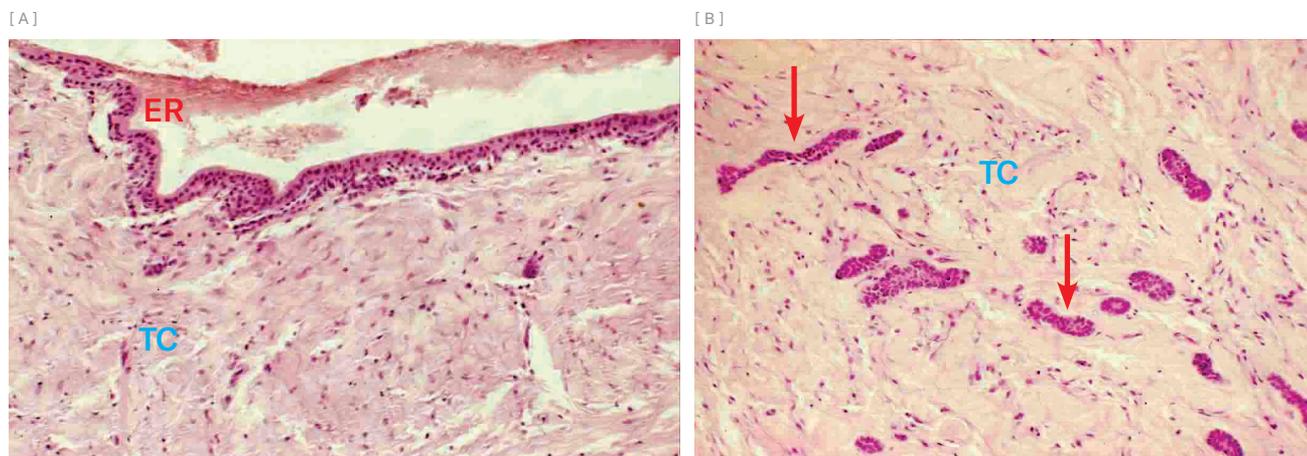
Unbroken tooth follicle: reduced enamel organ (ER) epithelium, membranous connective tissue (CT) and odontogenic epithelial remains (arrows) (HE: 10 and 25X).
